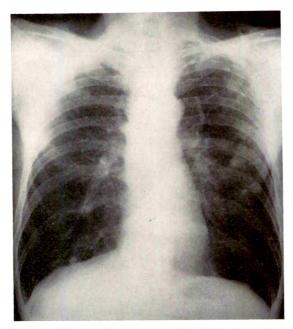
Standard posteroanterior chest roentgenogram showing typical Caplan nodules. This subject had anarthritic rheumatoid pneumoconiosis as a complication of asbestosis. (Reproduced with permission from *Thorax*.³)
